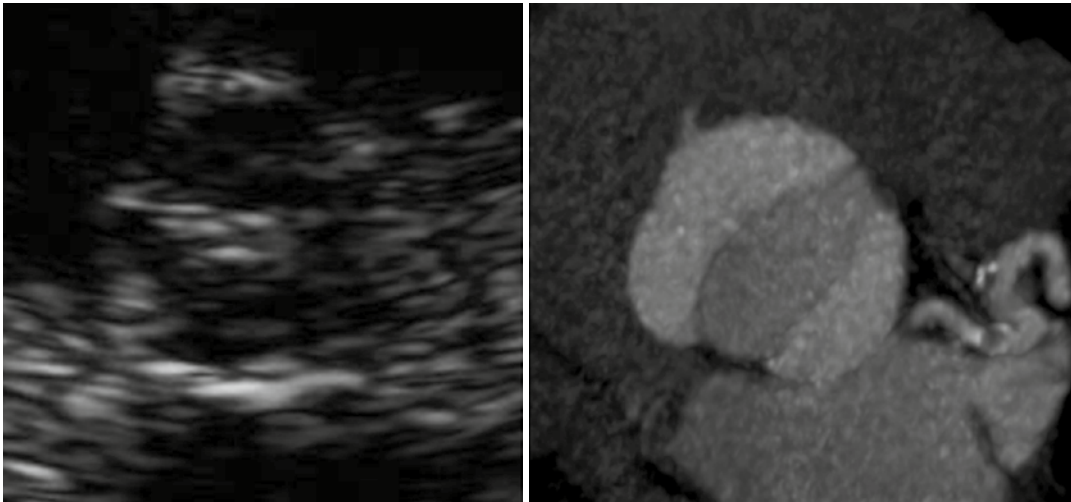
Mid-systolic phase short axis aortic valve image from TTE (*left*) and corresponding CTA (*right*) from the same patient with a bicuspid aortic valve. Due poor acoustic windows, the aortic valve was difficult to
